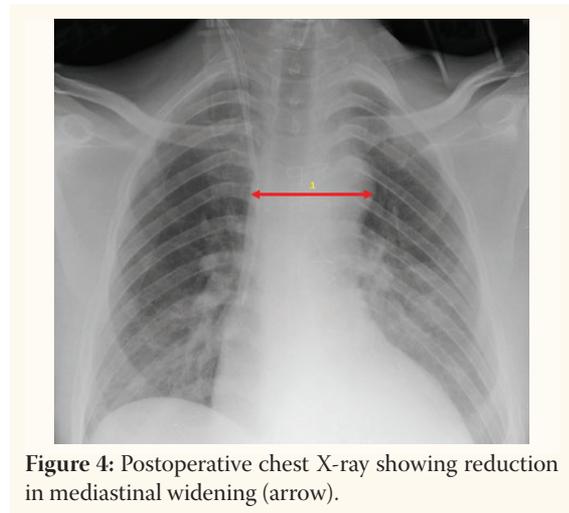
Postoperative chest X-ray showing reduction in mediastinal widening (arrow).
